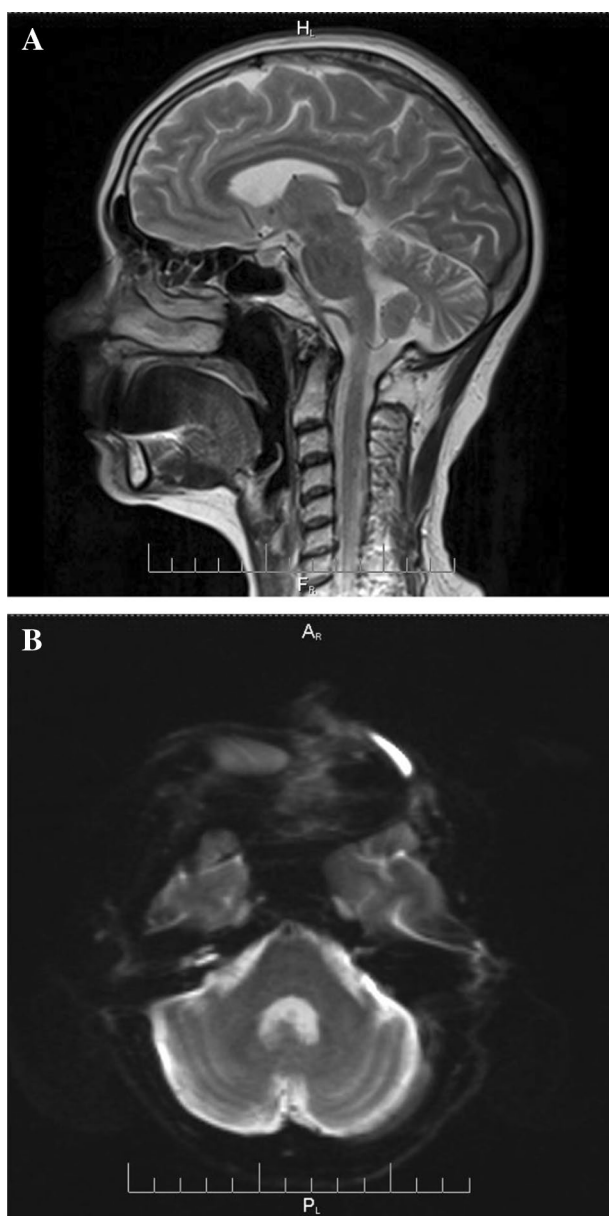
MRI showed mild cerebellar atrophy with no evidence of focal pathology. a T2W imaging, b diffusion-weighted imaging
